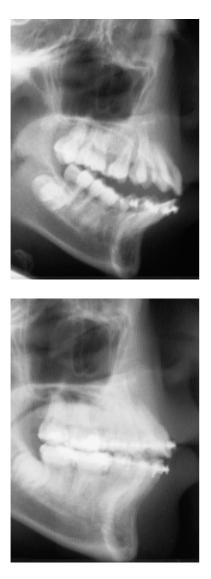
(a,b) Case 2: post-twin-block and near end-treatment lateral cephalometric radiographs.
